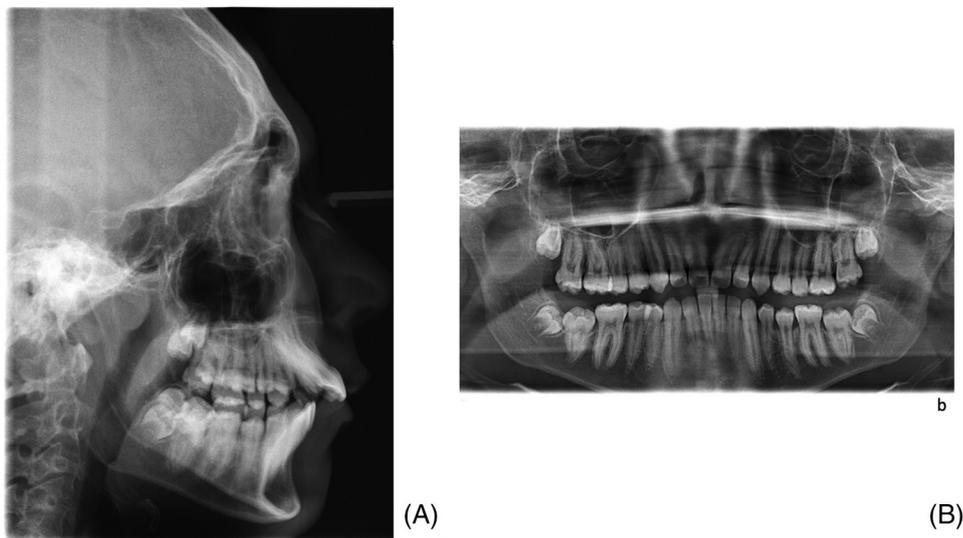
In-treatment diagnostic records - cephalometric (A) and panoramic (B) radiographs
